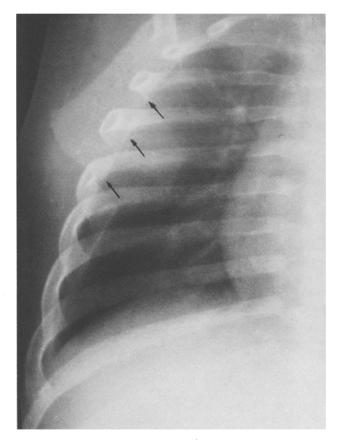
Case 1. Chest radiograph 2 days after admission. There is obvious inward displacement of the pleural line adjacent to the soft tissue swelling in the lateral chest wall. The diagnosis of osteomyelitis of the rib was entertained although no bony changes are seen
